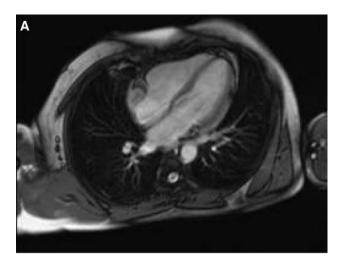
Bright-blood (A) and black-blood (B) magnetic resonance images at the midventricular level (8 months after initiation of antituberculous therapy). The soft tissue masses along the right and left ventricular free walls have almost completely disappeared. The right atrial mass is markedly reduced in area and is much less impressive; it now measures 5.9 cm². Likewise, the pericardial thickening has virtually disappeared.
